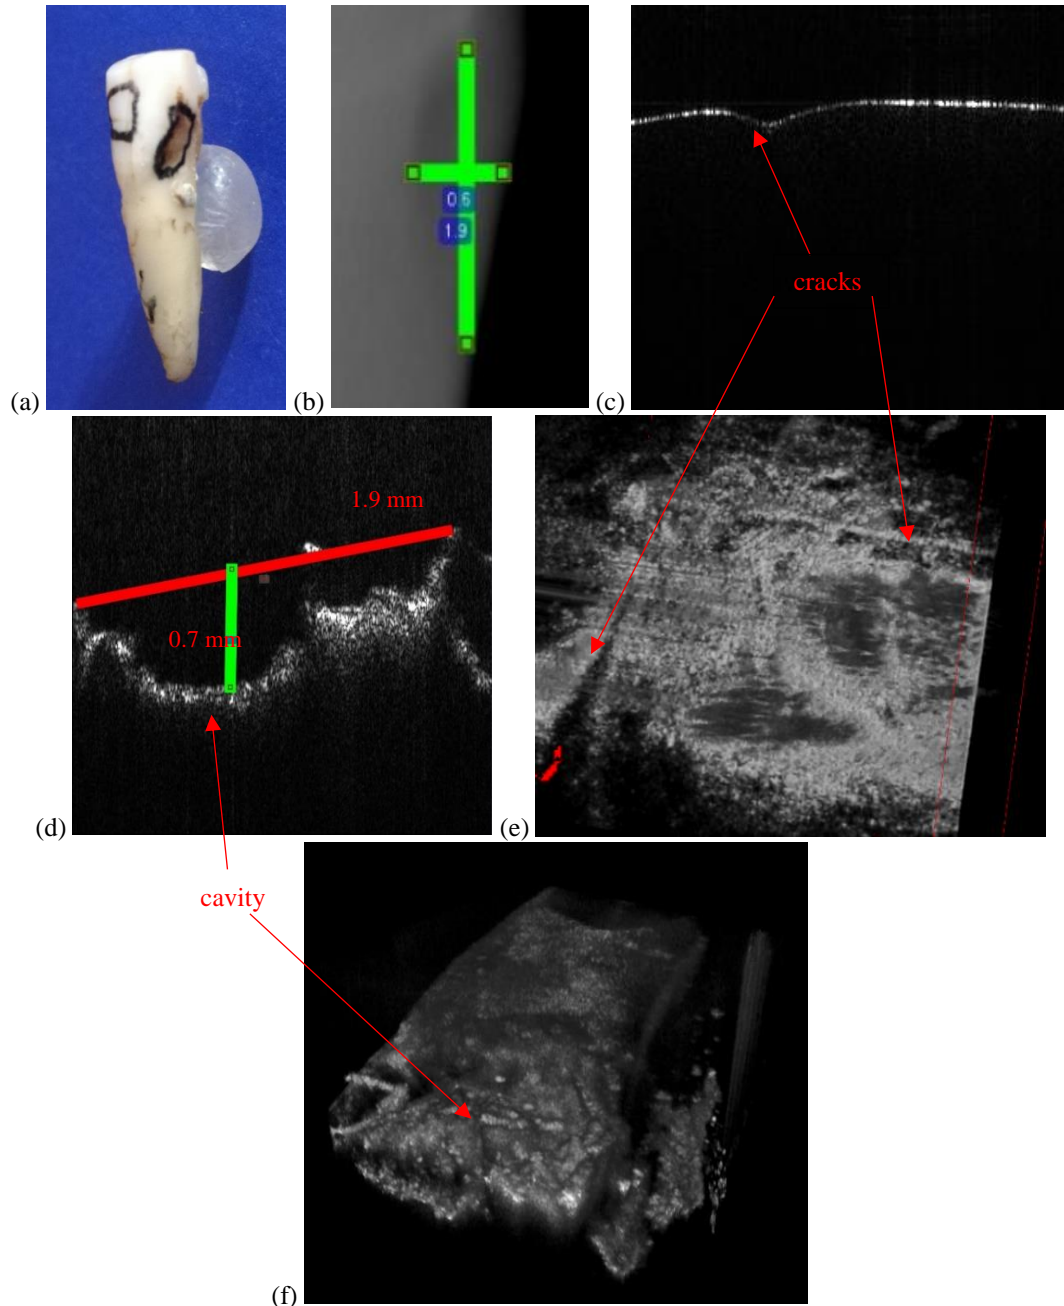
(a) Tooth number 4, marked for OCT investigations; (b) a section from the intraoral radiography with a focus on the measured cavity; (c), (d) OCT images where small cracks can be visible on the surface of the tooth number 4; (e), (f) OCT volumetric reconstructions of the cavity present in this tooth.
